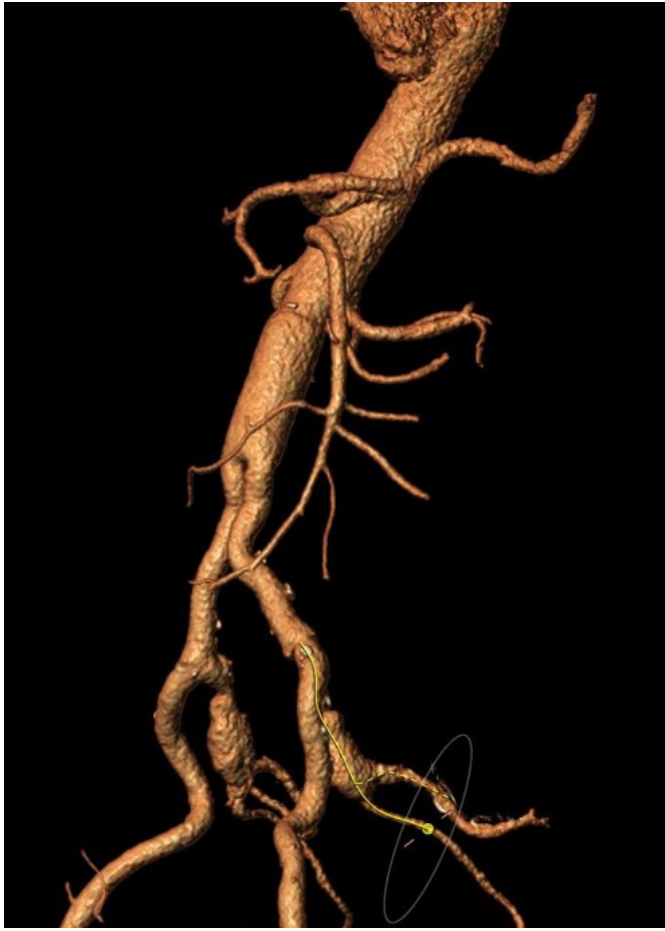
A computed tomography angiography (CTA) revealed bilateral internal iliac artery aneurysms (both sides 30 mm in diameter).
